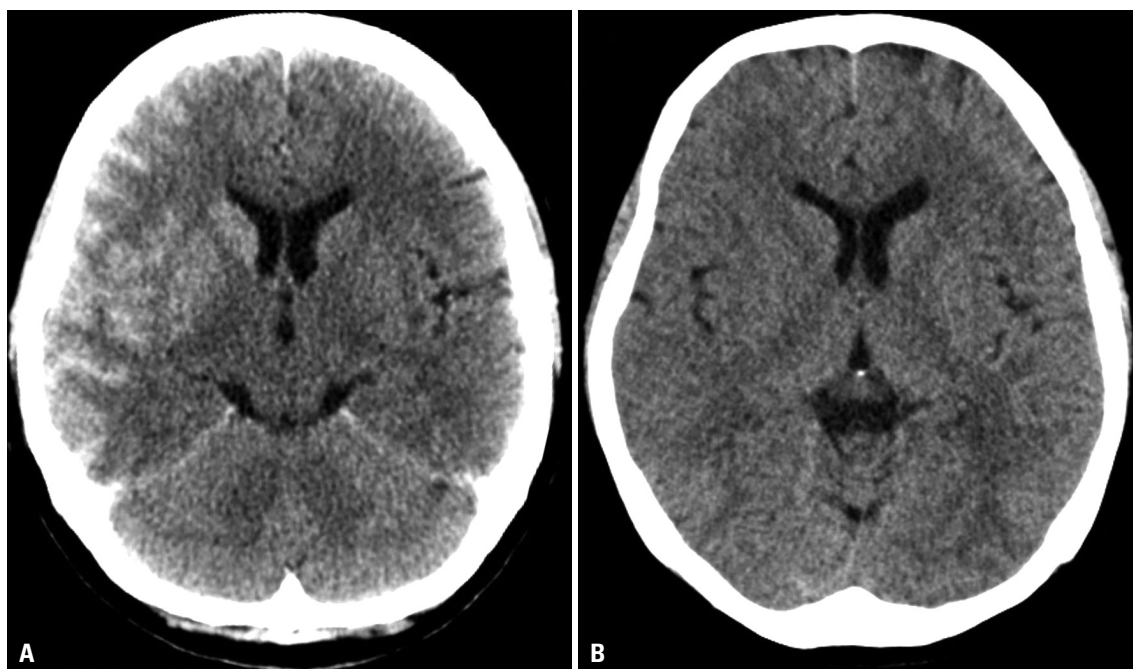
(A) Postangiographic brain computed tomography showing marked enhancement throughout the right cerebral cortex and right basal ganglia, indicative of contrast-induced encephalopathy. (B) Repeat brain computed tomography obtained after 24 hours demonstrating no enhancement on cerebral cortex and basal ganglia.
